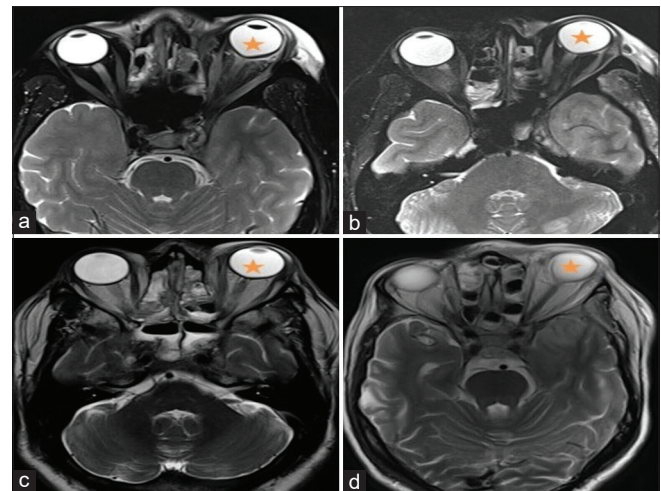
(a–d): T2-weighted orbital MR axial images of case 1 (a), case 2 (b), case 3 (c), and case 4 (d), showing “guitar pick sign” in the left-sided globe (brown star) MR = magnetic resonance
